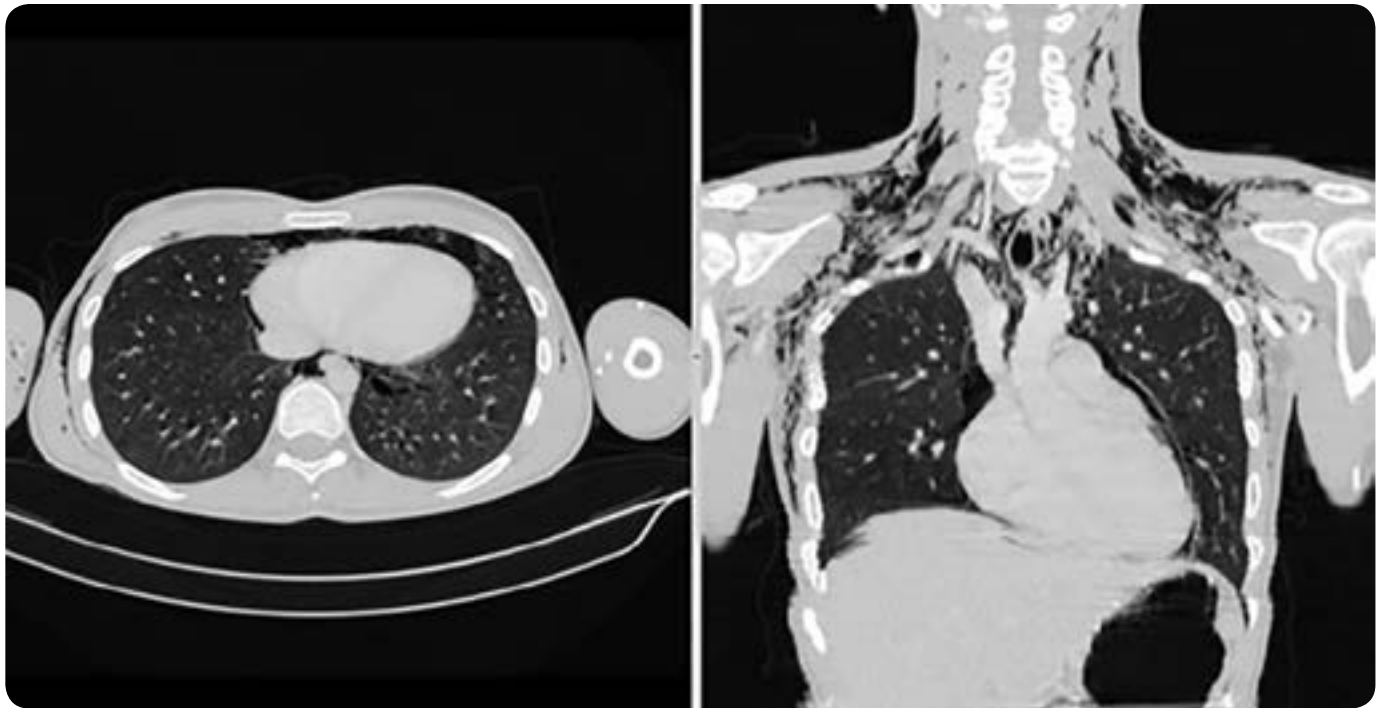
A 32-year-old patient with a history of marijuana and cocaine use. Axial and coronal cut of chest CT in which the Macklin effect is observed, with air extending towards the mediastinum and the cervix-thoracic subcutaneous space.
